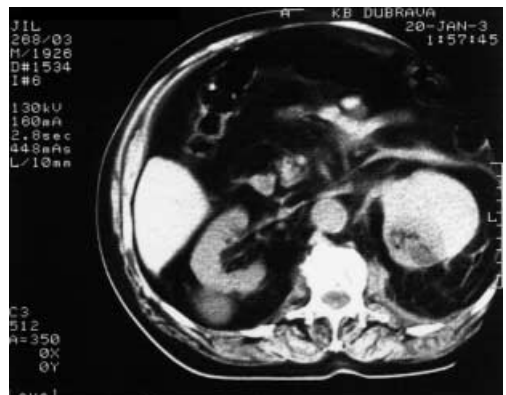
CT scan showed subcapsular haematoma without identifying the bleeding source.
